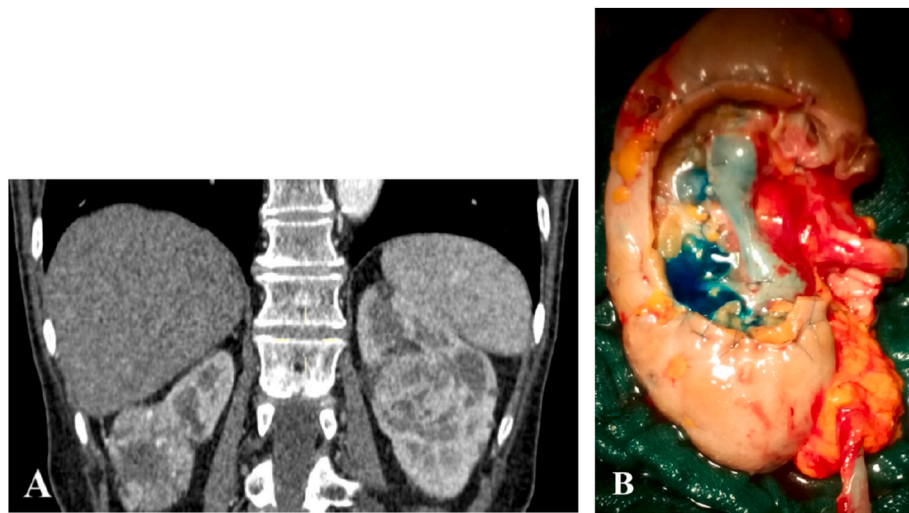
CT scan showing VHL-associated bilateral renal masses (A); left kidney after partial nephrectomy on the bench with methylene blue showing the integrity of the intrarenal collecting system (B).
